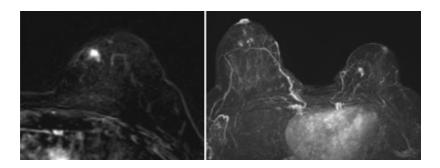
Dynamic Enhanced Breast MRI images show a suspicious enhancing lesion in the left breast.
